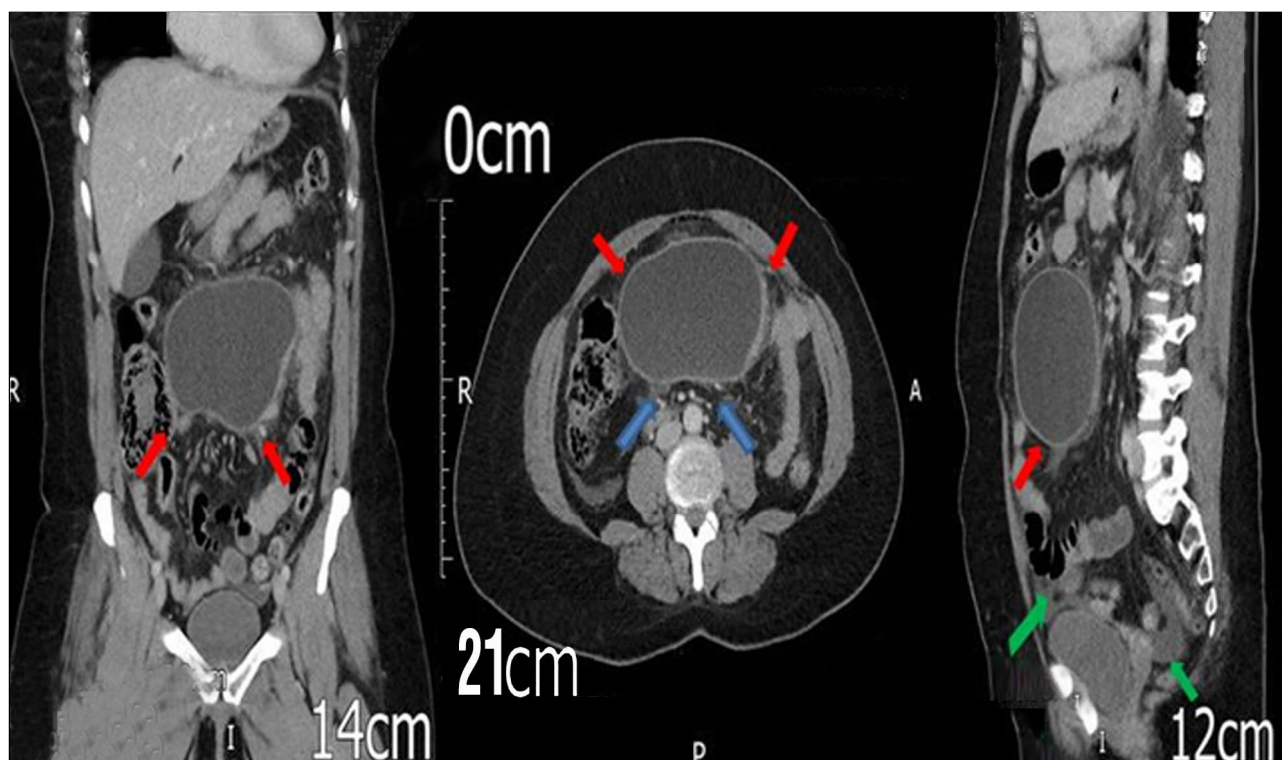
Compilation of the preoperative CT scan images, showing a large cystic lesion in close proximity to the mesenteric root (blue arrows), with extension to the hypogastrium (red arrows), with presence of free fluid in the pelvis (green arrows)
